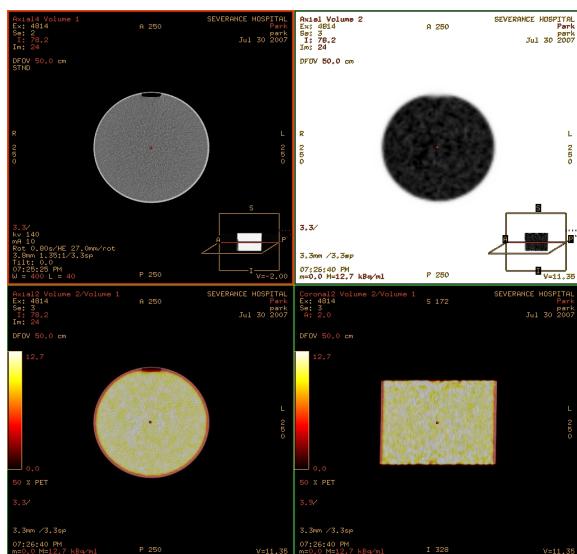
CT Image, PET Image and fusion Image
